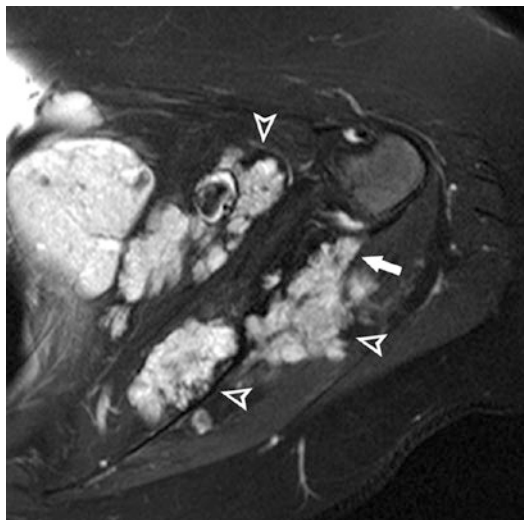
Angiomatosis: 43-year-old female with osseous abnormality of the scapula noted on chest radiograph. T2-weighted image with fat saturation (TR2181, TE60) shows a large lesion with features of serpentine vascular channels (arrowheads) involving multiple compartments and the scapula (arrow)
